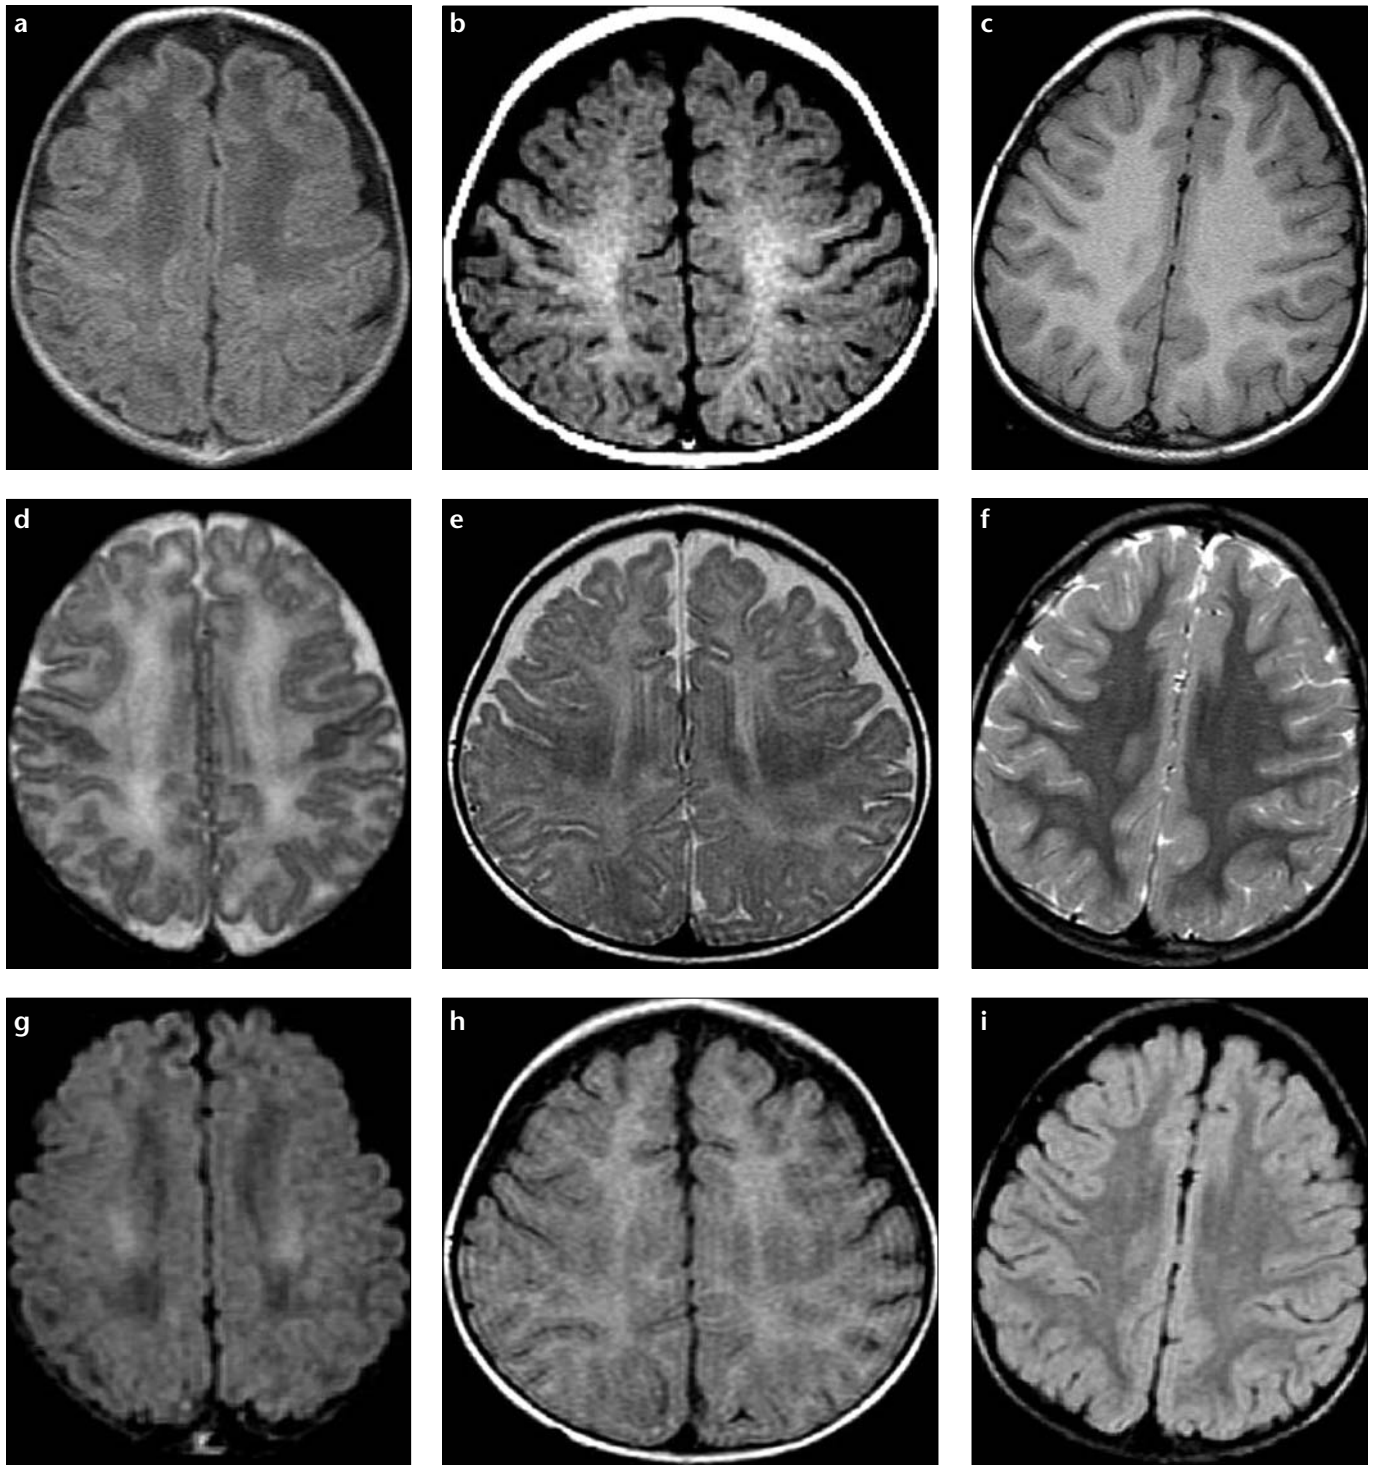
a-i. On transverse T1W (a-c), T2W (d-f), and FLAIR (g-i) MR images of an 8-day-old newborn (a, d, g), 6-month-old infant (b, e, h), and 25-month-old infant (c, f, i), signal changes were observed in the myelinated white matter tracts in the centrum semiovale at the level of the paracentral gyrus. These areas, which were hyperintense from birth on T1W images (a-c), are hyperintense on T2W images in the newborn (d) and hypointense in the sixth month (e) and the twenty-fifth month (f). Signal changes similar to T2W images were observed on FLAIR sequences (i).
